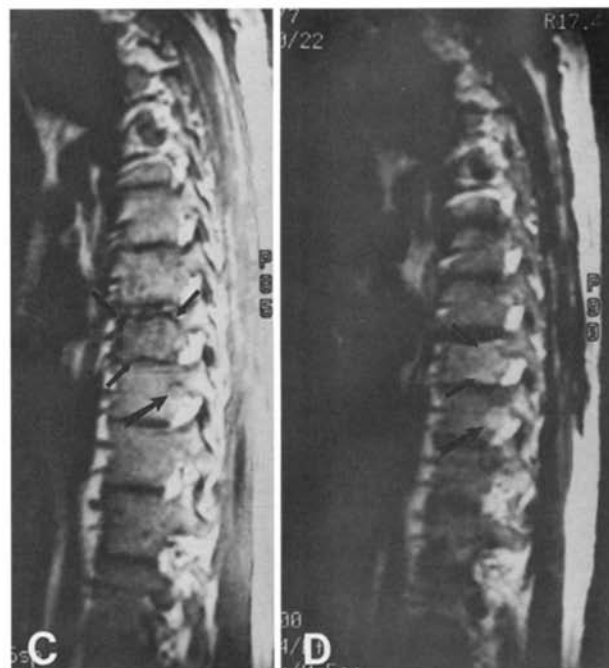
(A) Conventional radiograph of the lumbar spine shows sclerotic changes in the L-1 vertebra (arrow). (B) MR image (600/20) shows fatty marrow replacement in L-1, as well as multiple well-defined areas of disease throughout the spine (arrows).
